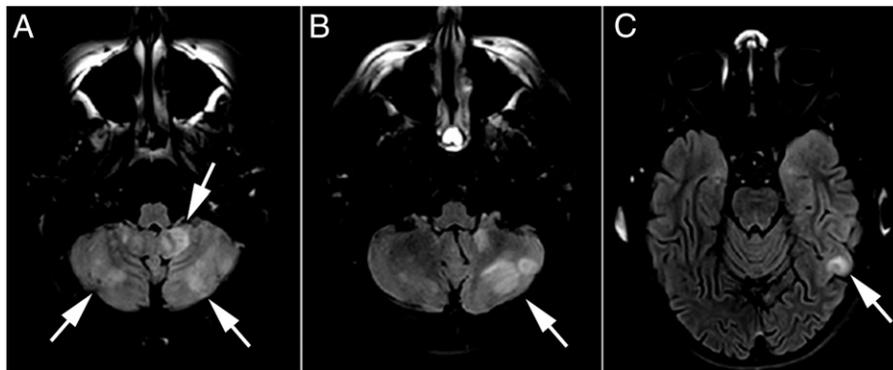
Presurgical brain magnetic resonance images showing vasogenic subcortical edema in the bilateral cerebellar hemispheres (A and B) and the left temporal lobe (C) consistent with posterior reversible encephalopathy syndrome.
